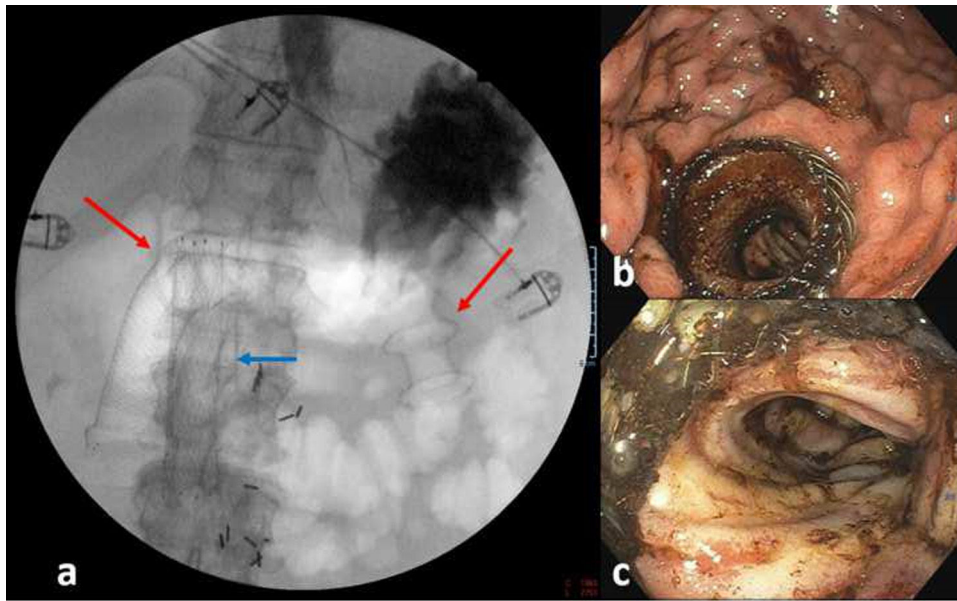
(a) Fluoroscopy during endoscopic ultrasound guided gastrojejunostomy (right red arrow) in a patient with previous uncovered duodenal self-expandable metal stent (left red arrow) and endovascular stent (blue arrow). (b) Endoscopic image of the lumen-apposing metal stent. (c) Ulcerative jejunitis.
